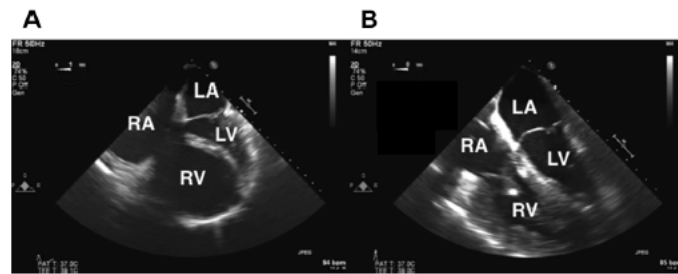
Midesophageal 4-chamber view shows a severely dilated right ventricle (RV) with shift of the interventricular septum toward the left impinging on the left ventricle (LV) and likely impeding adequate filling and function (A) in a patient with severe pulmonary hypertension. (B) The same echocardiographic view after lung transplantation showing a hypertrophied, dilated RV but with a midline positioned interventricular septum. LA, left atrium; RA, right atrium.
